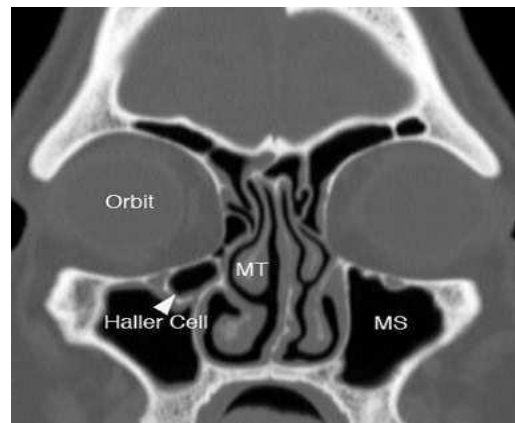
Coronal CT image showing haller cell
